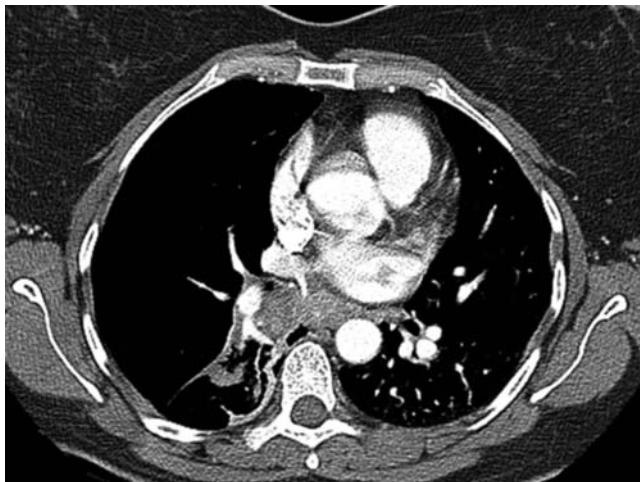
Atypical carcinoid. CT scan of chest showing a tracheal mass at the bifurcation site with near total obliteration of its lumen. There is also distal atelectasis of the superior segment of the right lower lobe. Biopsy showed atypical carcinoid.
